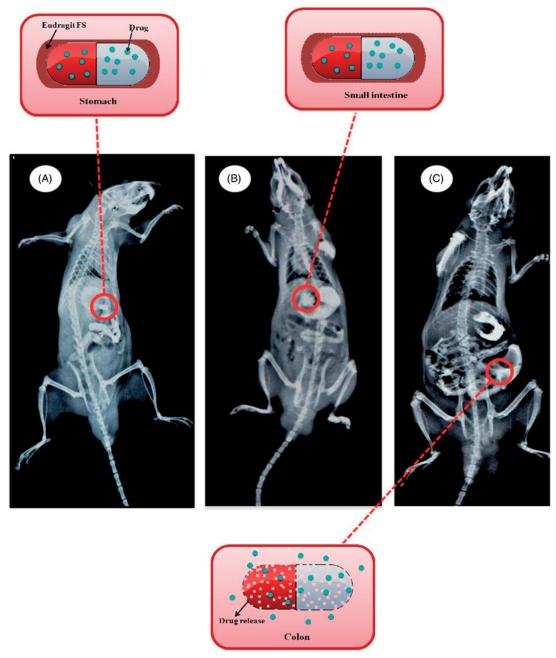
X-ray images of the movement of an enteric coated capsule (A) from the stomach (B) to the small intestine, and (C) to the colon.
